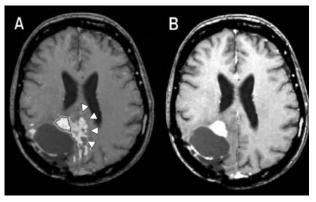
Multimodal imaging for the establishment of imagingguided experimental treatment strategies. Coregistration of [<sup>18</sup>F]FIAU-, [<sup>11</sup>C]MET-, [<sup>18</sup>F]FDG-PET and MRI before (left column) and after (right column) targeted application (stereotactic infusion) of a gene therapy vector. The region of specific [<sup>124</sup>]]-FIAU retention (68 h) within the tumor after LIPO-HSV-1-*tk* transduction (white arrow) resembles the proposed tissue dose of vector-mediated gene expression and shows signs of necrosis (cross right column; reduced methionine uptake [MET] and glucose metabolism [FDG]) after ganciclovir treatment. Reproduced with permission from Jacobs et al. Positron-emission tomography of vector-mediated gene expression in gene therapy for gliomas. *Lancet* 358:727–729. Copyright © 2001, Elsevier Limited. All rights reserved.<sup>120</sup>
